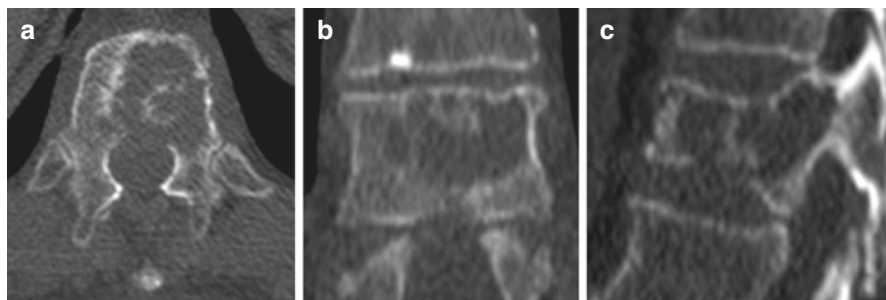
An osteolytic lesion located within the D12 vertebral body in a 72-year-old patient with multiple myeloma: CT multiplanar reformation on axial (a), coronal (b), and sagittal (c) plans
